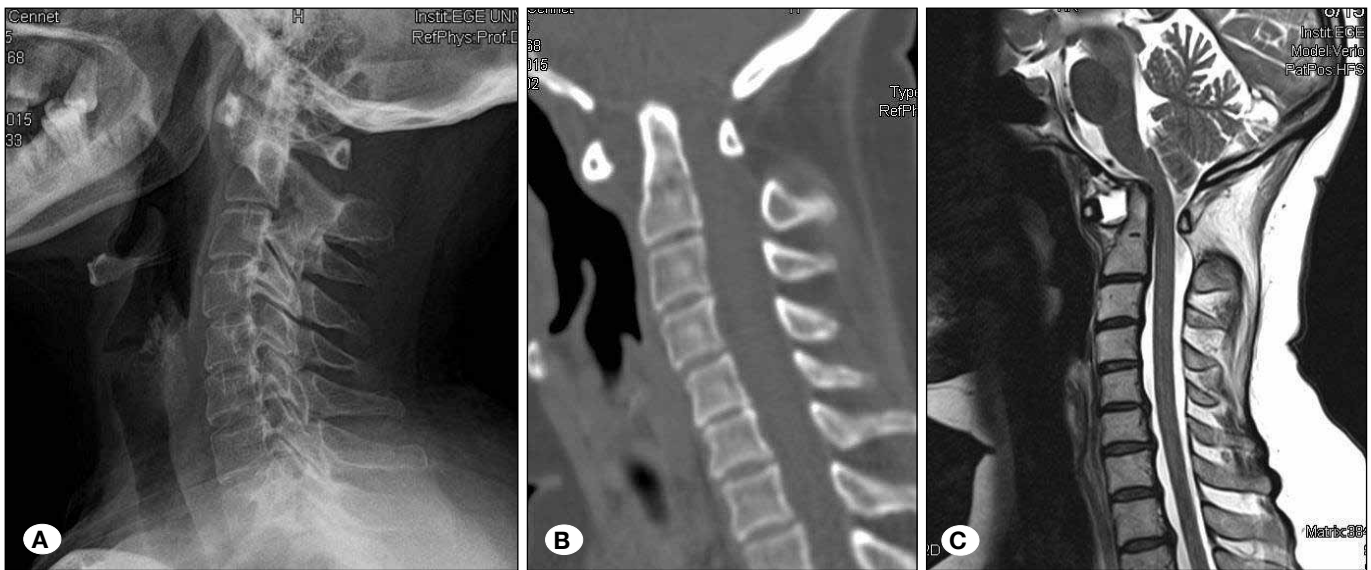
Lateral cervical x-rays (A), sagittal CT scan (B) and sagittal T2-weighted MRI (C) demonstrate atlantoaxial instability.
